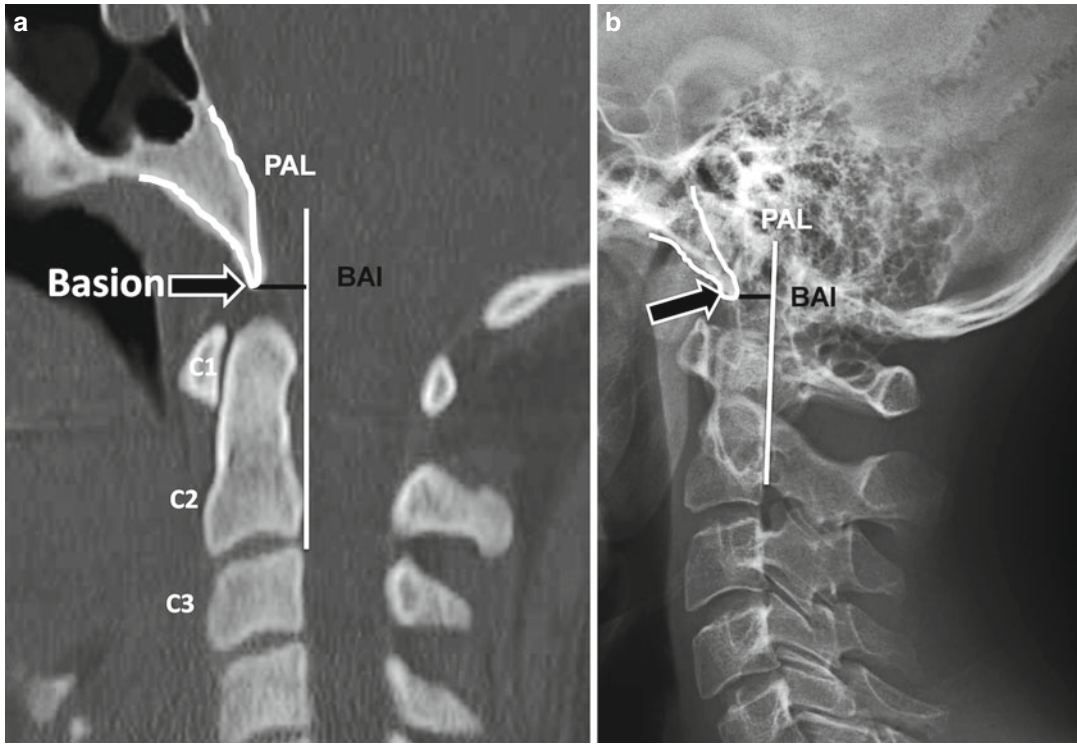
Sagittal CT reconstruction (a) and lateral cervical spine radiograph (b) demonstrating the basion-axial interval (BAI). Basion-axial interval is the distance
